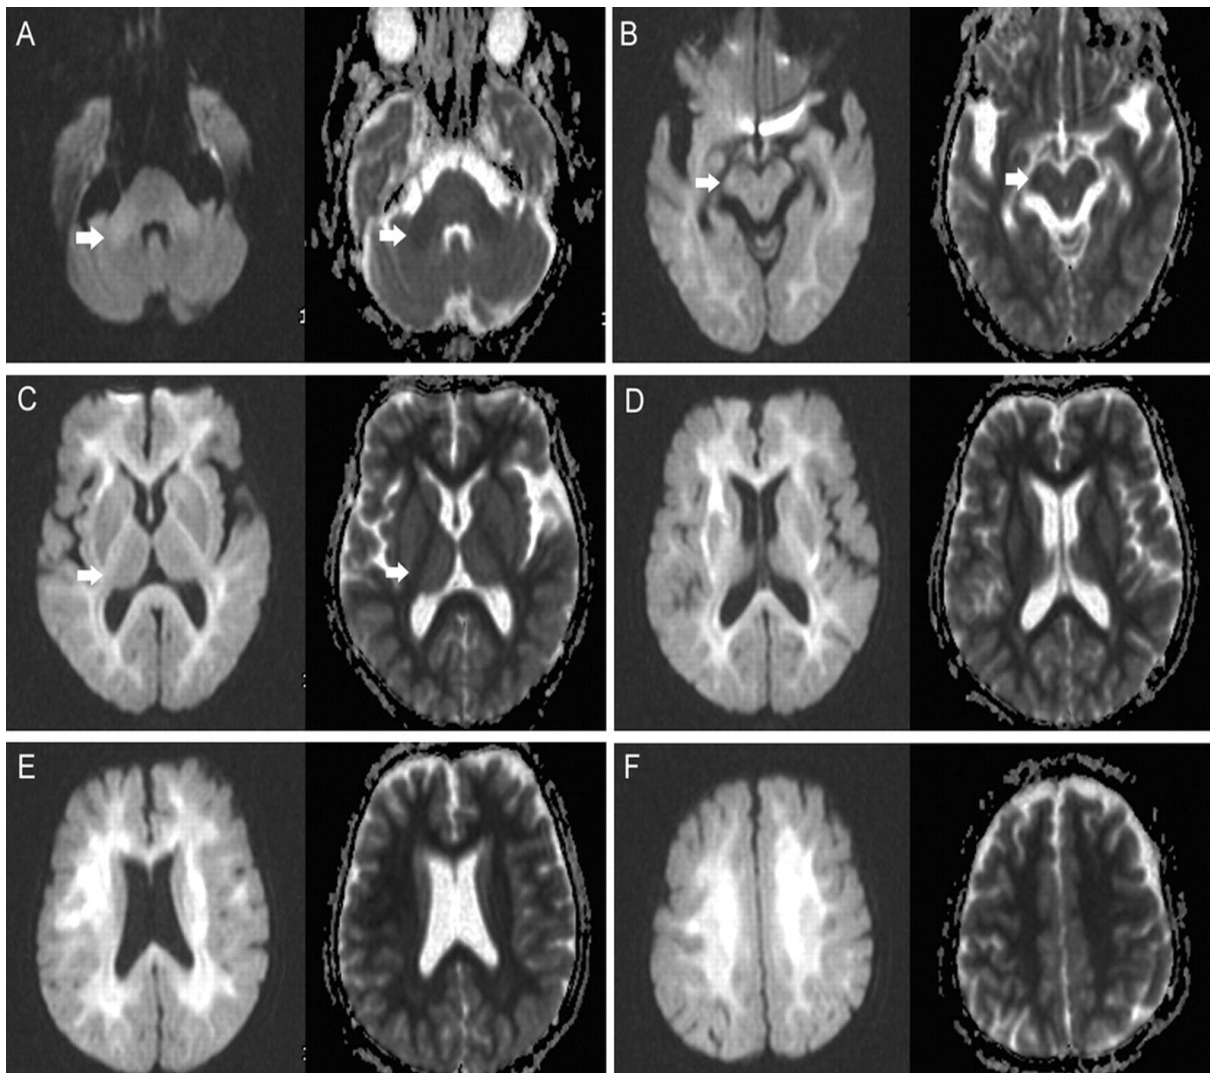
Diffusion-weighted MR images and the corresponding apparent diffusion coefficient maps (A through F). Areas of restricted diffusion are evident in the middle cerebellar peduncle (A, white arrows), cerebral peduncle (B, white arrows), and internal capsule (C, white arrows). The periventricular and subcortical white matter are also affected extensively (C through F) (reproduced from Kim and Koh, 2007).
